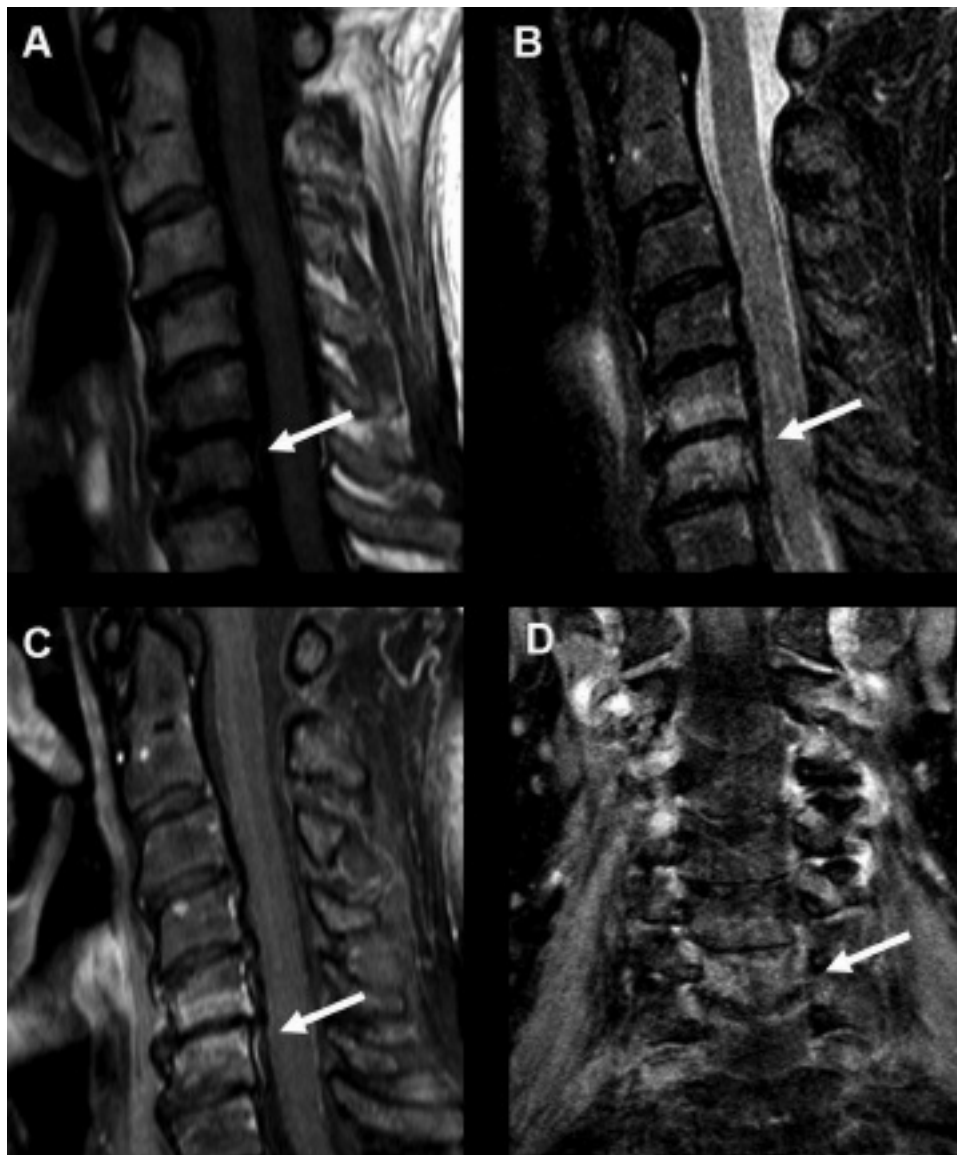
A. Sagittal T1-weighted image. B. Sagittal short-tau inversion recovery image. C. Sagittal T1-weighted postcontrast image. D. Coronal VIBE (volumetric interpolated breath-hold examination) image. Note bone marrow edema at C5 and C6 (arrows).
